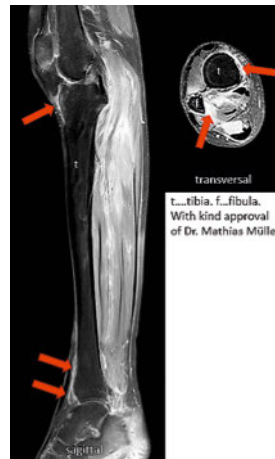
MRI Periostitis.
